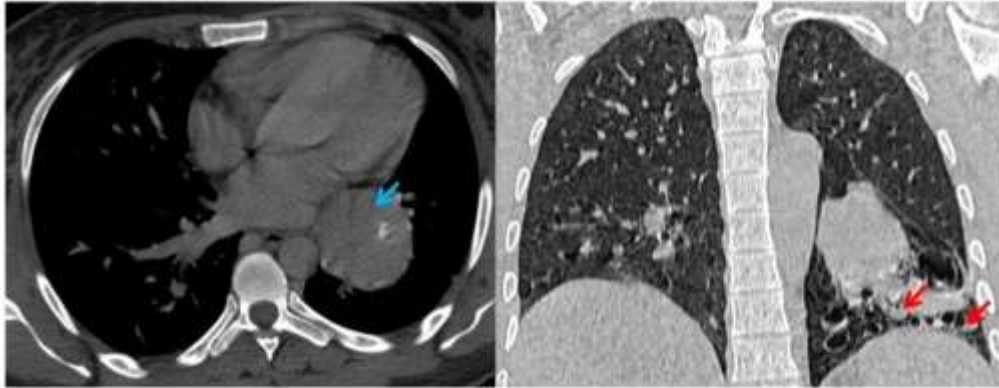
Typical carcinoid in a 36-year-old woman with a 2-year history of cough and recurrent pneumonitis. Contrast-enhanced Chest CT with mediastinal window demonstrates a single mass in the left lung base (blue arrow) that causes narrowing of the left lower bronchus. Chest CT with lung window shows several bronchiectasis distal to the tumor site, some occupied by mucus (red arrow).
